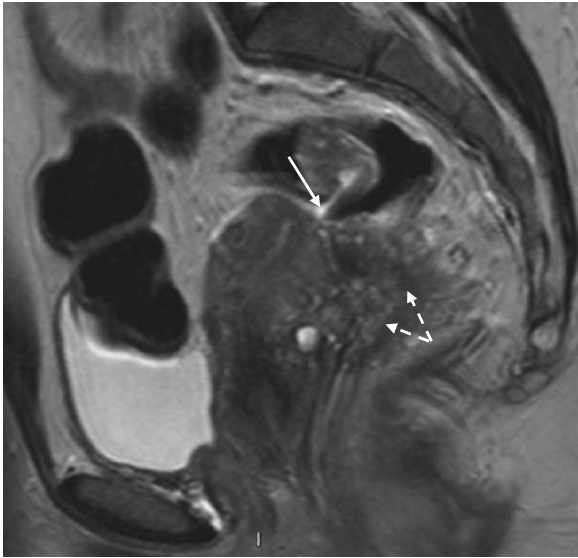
MRI T2W. Adhesions of bowel to endometriotic plaque (*arrow*) at cervico-uterine junction in Pouch of Douglas with obliteration of the peritoneal recess. Note large endometriotic deposit (*broken arrows*) invading rectum, clinically potentially mistaken for tumour
